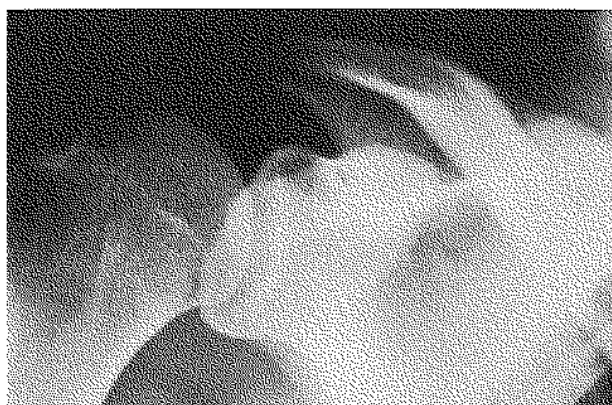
An anteroposterior radiograph of the right shoulder failed to show the fracture.
